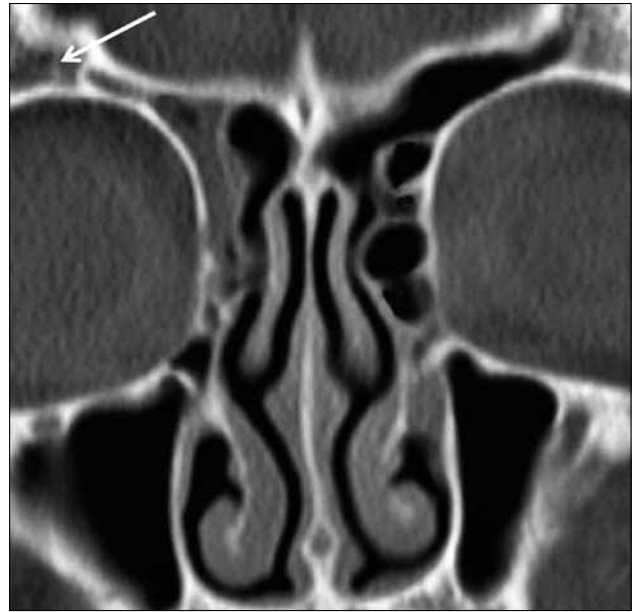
CT scan examination, coronal section - frontal sinusitis (ENT Department property).
